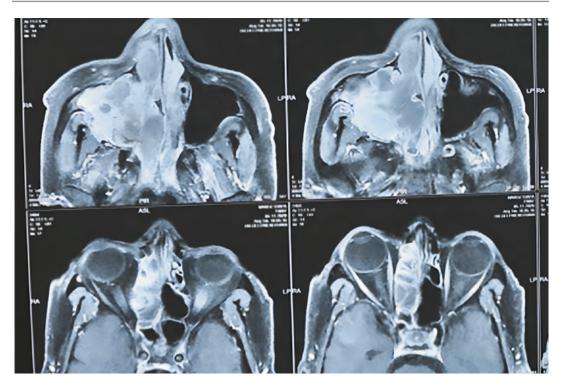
MRI scan: an axial view showing an extensive lesion involving the right medial wall of the maxilla and the lesion extending into the right maxillary, right anterior ethmoid and right nasal cavity
